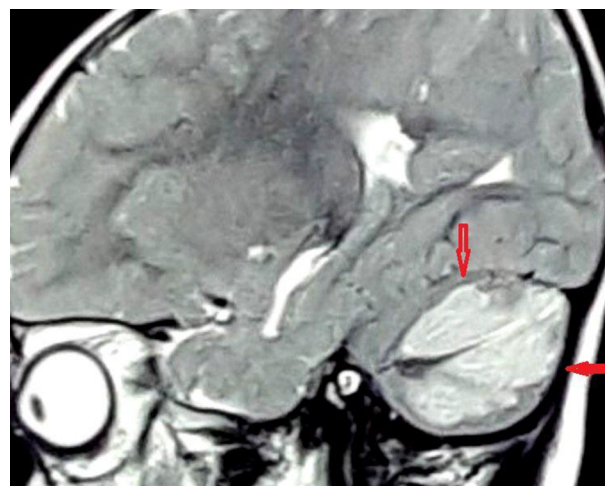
Sagittal T2 Magnetic Resonance Imaging Indicating Diffuse High-Signal Lesions in Cerebellar Hemispheres Consistent With Severe Cerebellar Edema
